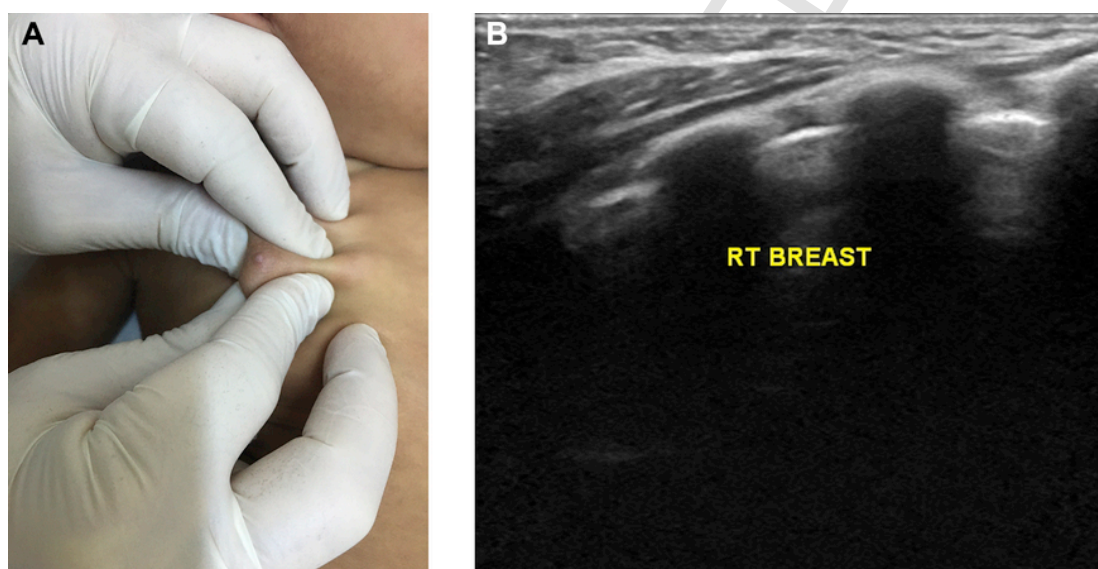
a: Right breast enlargement and nipple discharge has been resolved. b: Right breast ultrasonography showing disappearance of the cystic lesion.
